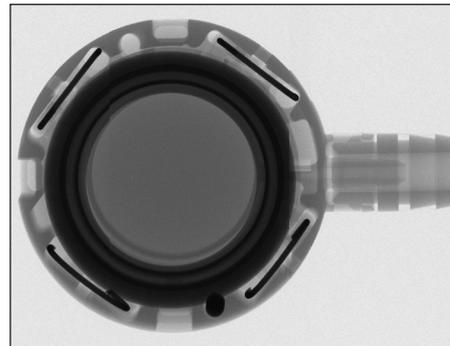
Top or bottom view x-ray image of the LAP-BAND AP® System Large with RapidPort® EZ Access Port
